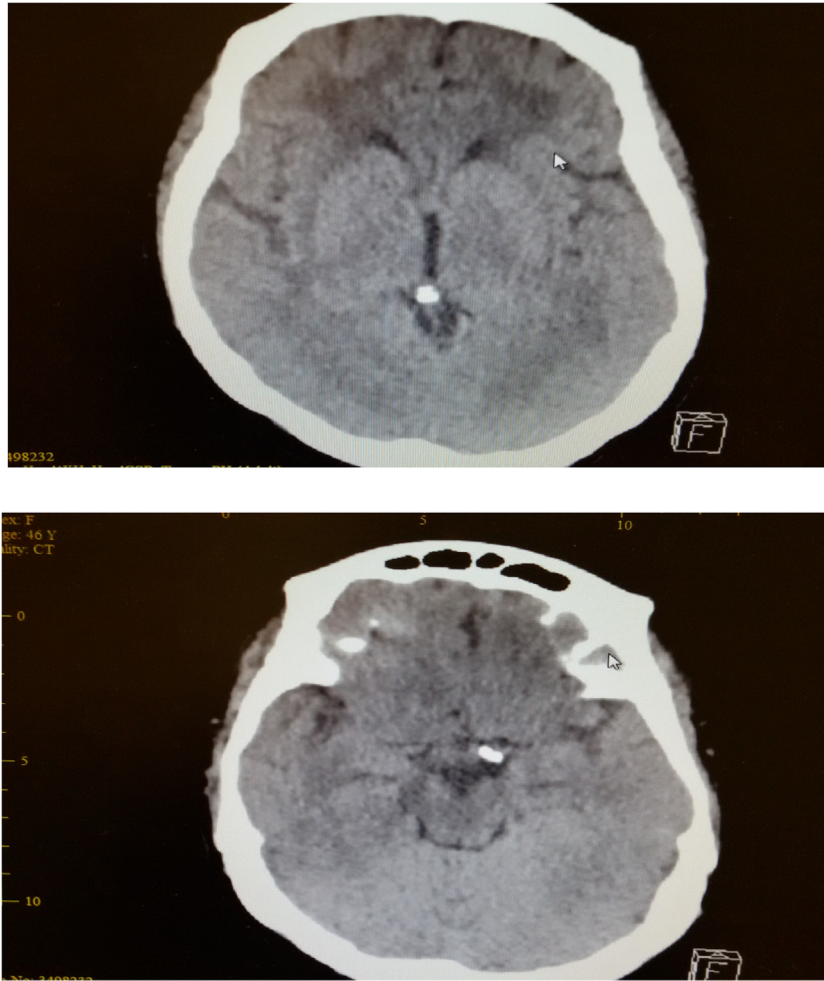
This is computed tomography scan picture for the patient after admission which showed multiple bilateral hypodensities in the distribution territories of both vertebral arteries with no apparent gross brain oedema or hemorrhage.
